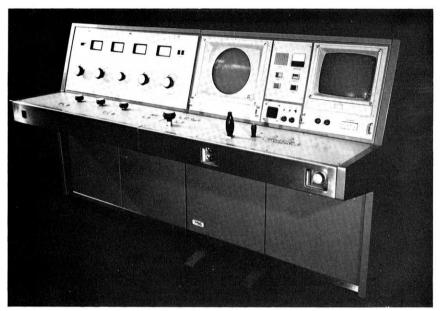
The control desk of the x-ray television installation for mass survey of gastroduodenal diseases.
